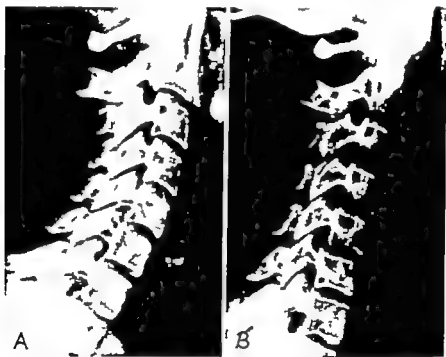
Radiographs of a cervical spine without traction is shown in (A) and with thirty five pounds of traction in (B). With thirty-five pounds of pull the cervical spine is straightened and there is visible distraction of the vertebrae. The size of the intervertebral canals is definitely increased.
